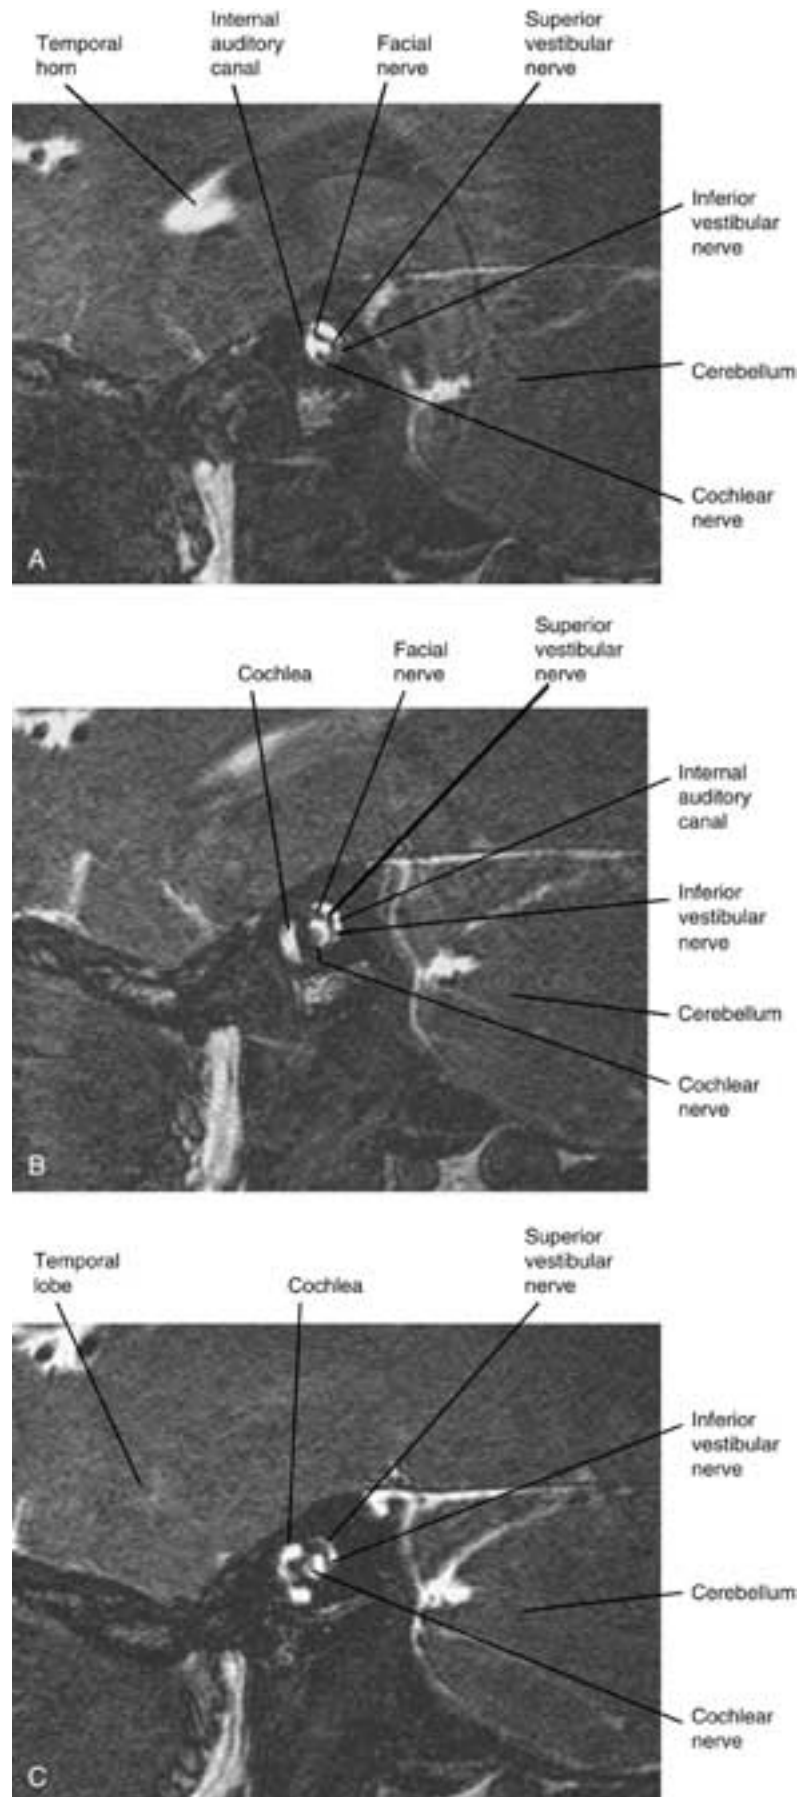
A to G, Sagittal MR imaging from medial to lateral. The facial nerve and the branches of the vestibulocochlear nerve are seen in the IAC in the medial images. The facial nerve travels in the anterior superior aspect of the canal. The cochlear nerve lies in the anterior inferior portion of the canal. The superior and inferior vestibular nerves lie in their respective portions of the posterior canal. More laterally, fluid is seen in the vestibule and the semicircular canals.
